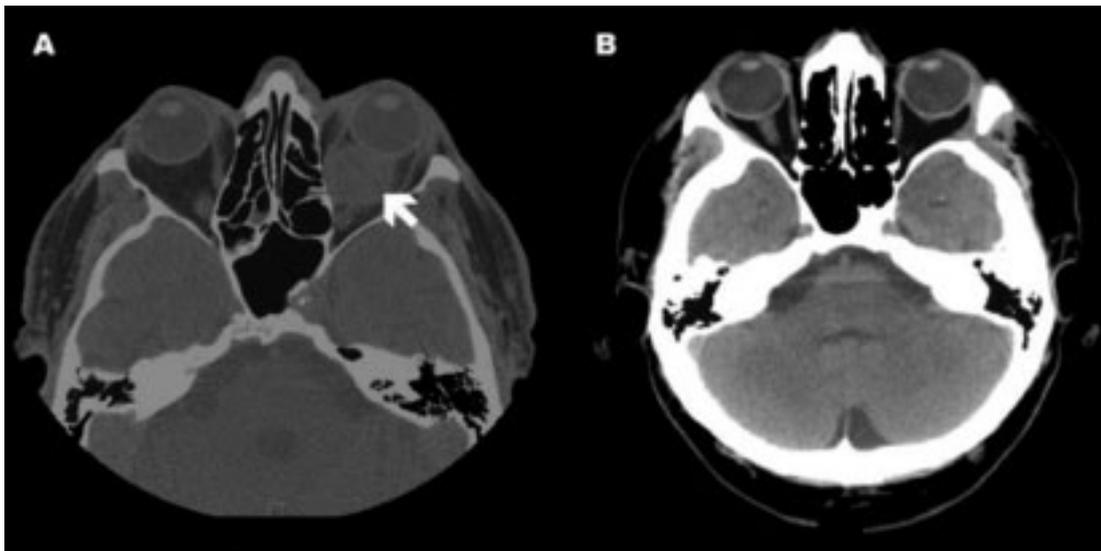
Axial CT scan of the head shows left retrobulbar mass (arrow in A) and no residual mass after operation (B)
